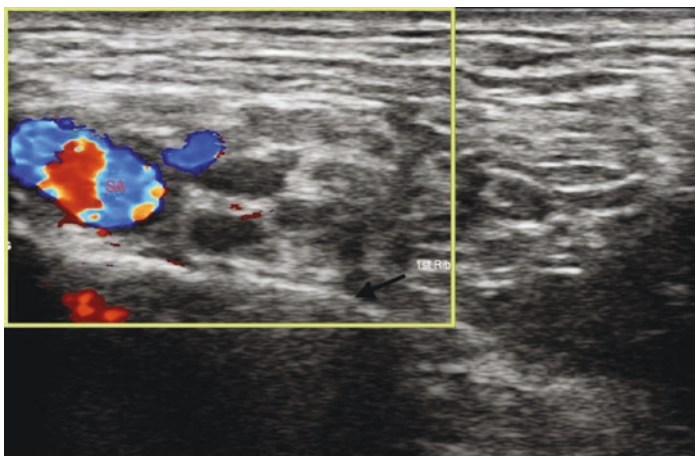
Subclavian artery visualized above the first rib. Color doppler shows an arterial branch within the brachial plexus
